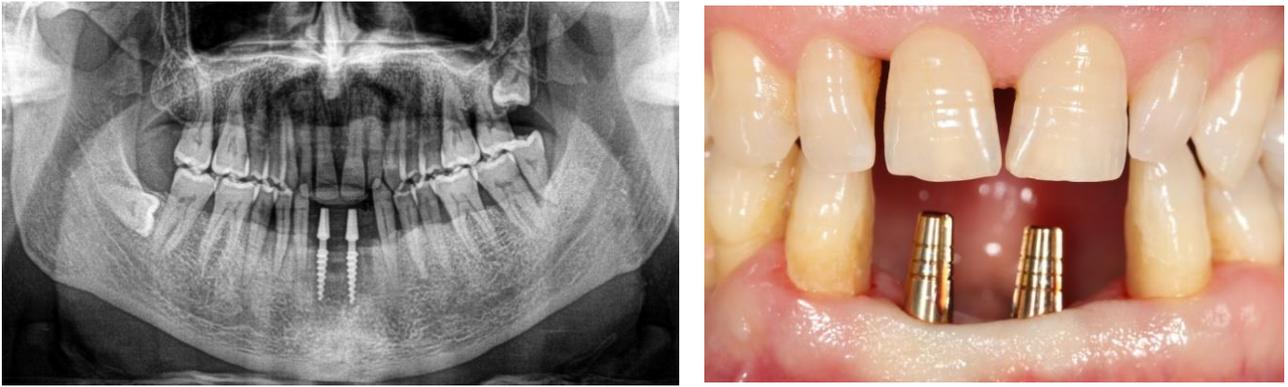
Clinical photo and panoramic radiograph of patient after implant placement
